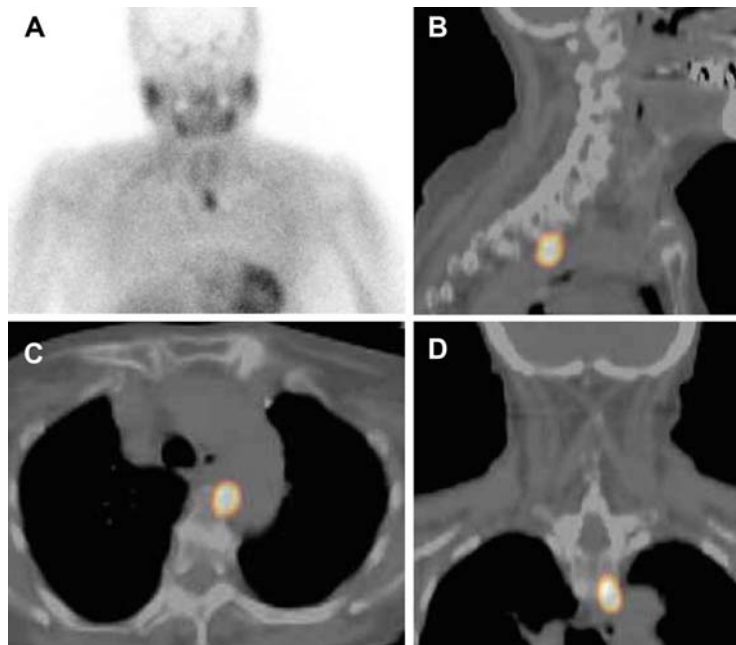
^{99m}Tc -sestamibi scintigraphy. (A) Planar images find a left inferior parathyroid adenoma. (B–D) SPECT images (sagittal, axial, and coronal imaging planes) help in the diagnosis of paraesophageal ectopic adenoma.
